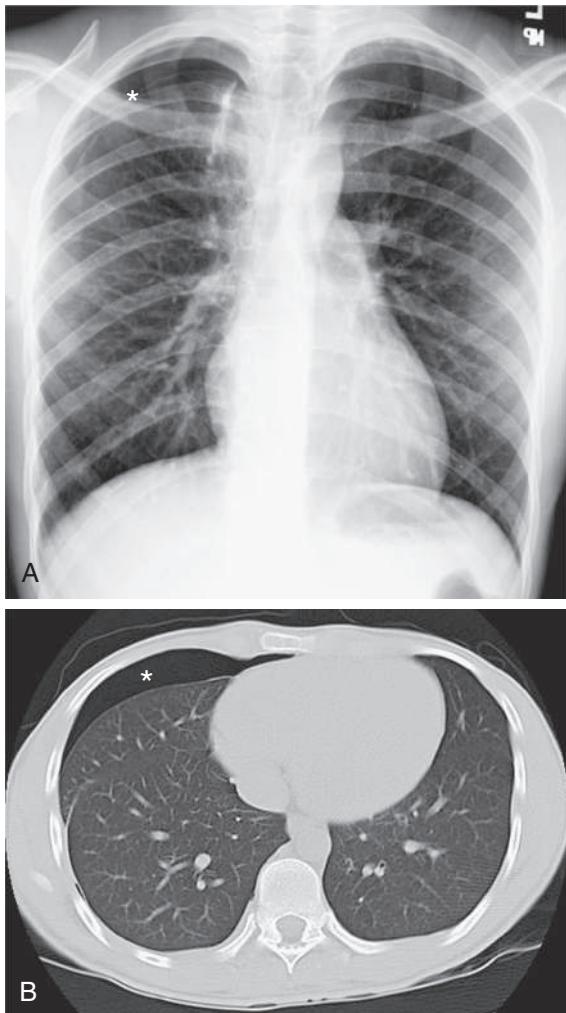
Teenager in whom a spontaneous right pneumothorax developed because of a bleb. Patient had a persistent air leak despite recent surgical resection of the causative apical bleb. Chest radiograph (A) and CT scan (B) clearly show the persistent pneumothorax (asterisk).
